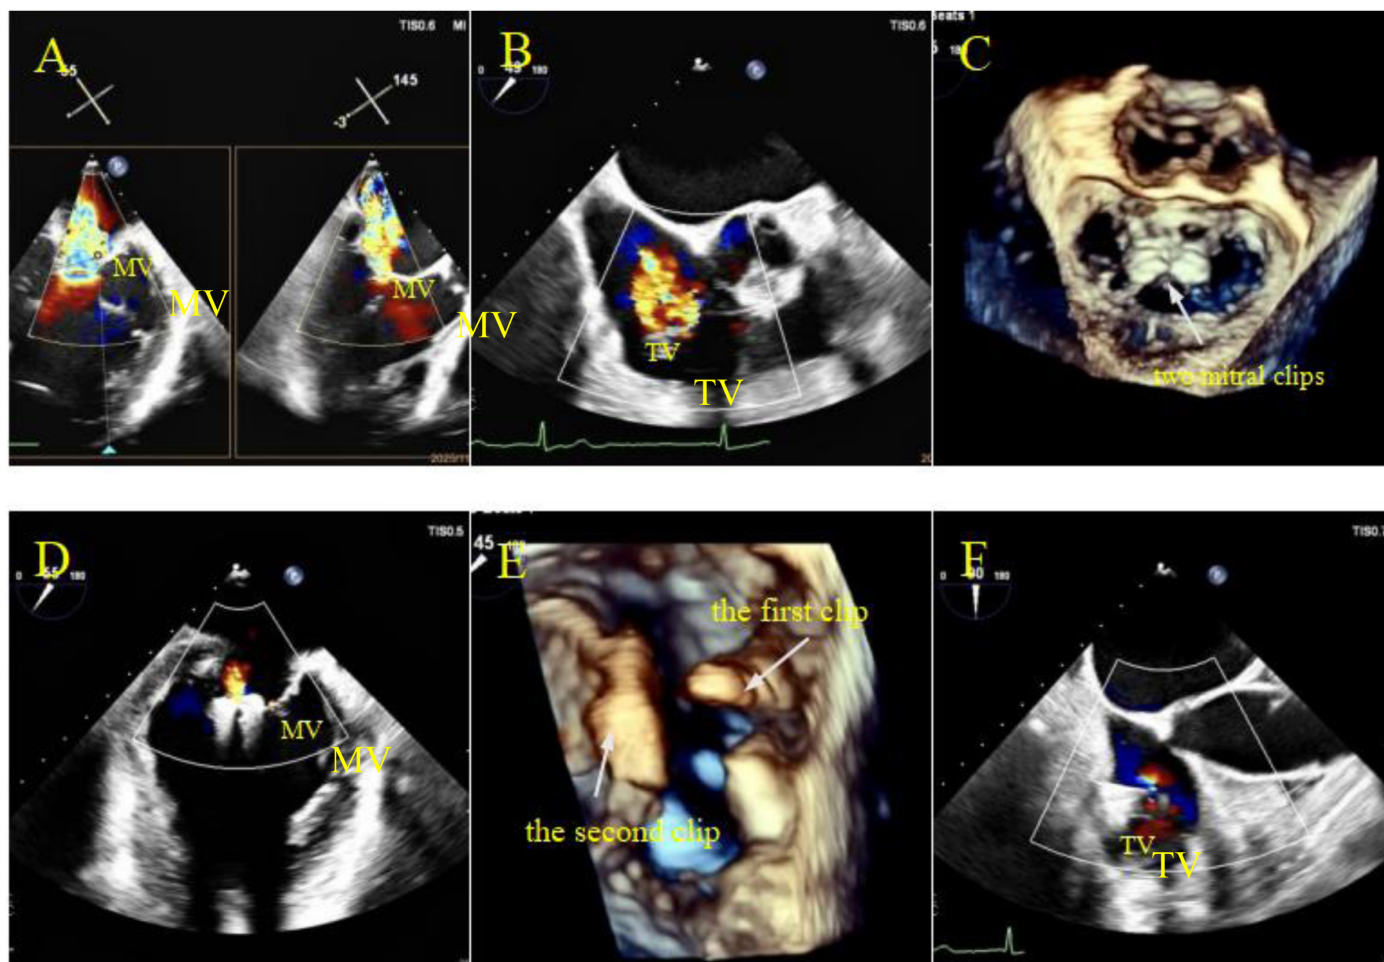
Pre-procedural transesophageal echocardiography (TEE) revealed severe mitral regurgitation with the primary jet origin from zone 2, extending to zones 1 and 3 (A), and severe tricuspid regurgitation (TR) (B). Intra-procedural 3-dimensional TEE showed the 2 implanted mitral clips (C). Post-procedural color Doppler imaging demonstrated mild residual regurgitation (grade 1+) between the 2 clips (D). Intra-procedural 3-dimensional TEE further confirmed the deployment of 2 tricuspid annuloplasty clips: the first clip (12T) was positioned at the 5:30 direction (posterior-septal commissure) on the tricuspid short-axis view, and the second clip (14T) was placed at the 7:30 direction (anterior-posterior commissure) (E). Post-procedural color Doppler imaging showed a reduction in TR from grade 4+ to grade 1+ (F).
